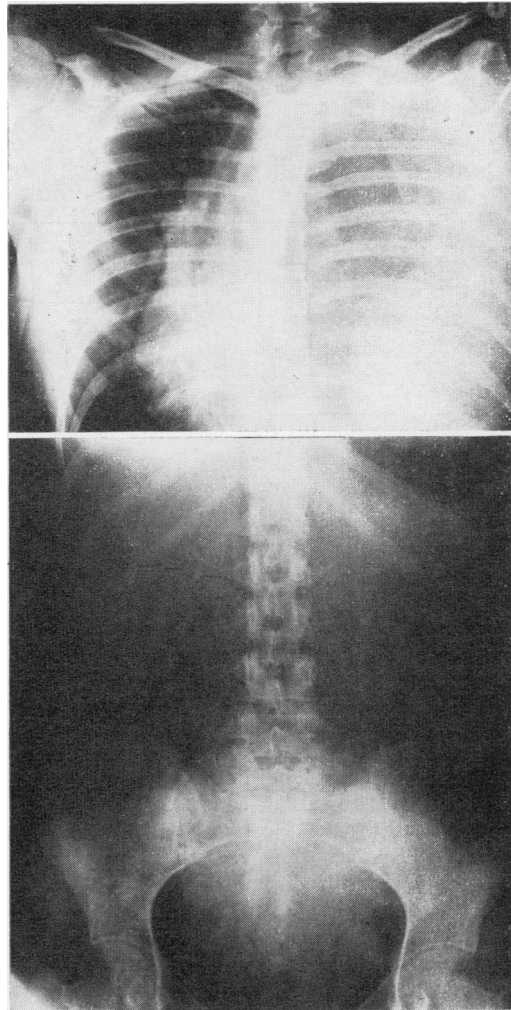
X-ray of chest and abdomen (13.9.67, 10 a.m.) showing mediastinal displacement by gas and fluid in the left pleural cavity, with inversion of the hemi-diaphragm and no gas in the intestine
